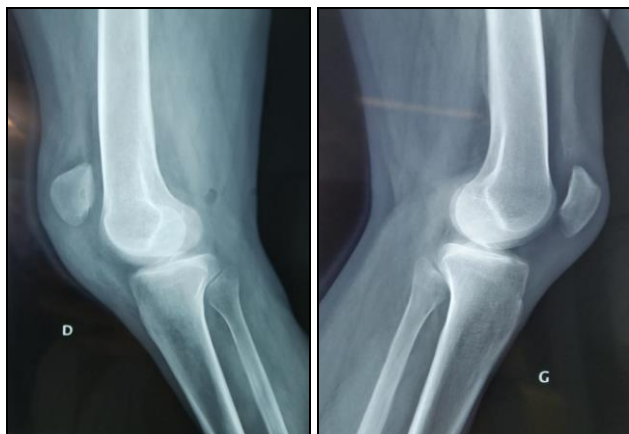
Lateral right and left knee radiograph at the time of injury.
